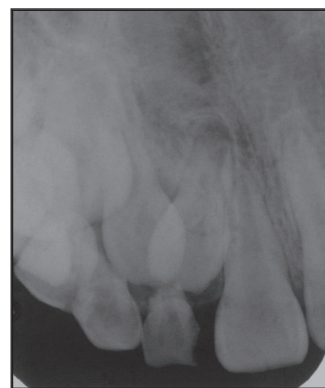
Case 1: A periapical radiograph, taken at the age of 8 years, 10 months, shows that a supplemental permanent lateral incisor is present.
